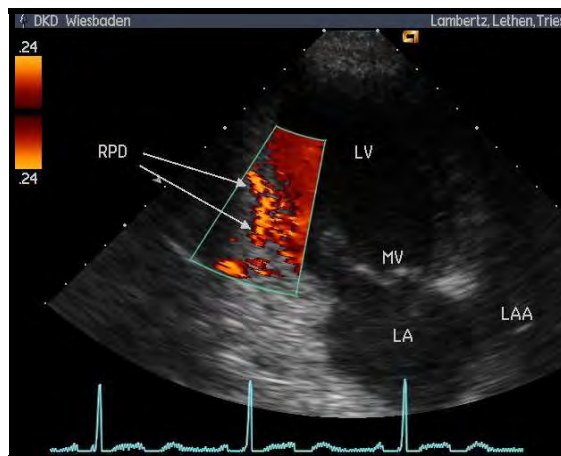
Modified apical two-chamber view. Color Doppler flow map showing the proximal part of the posterior interventricular branch in the posterior interventricular groove (Heinz Lambertz et al., 2004).
